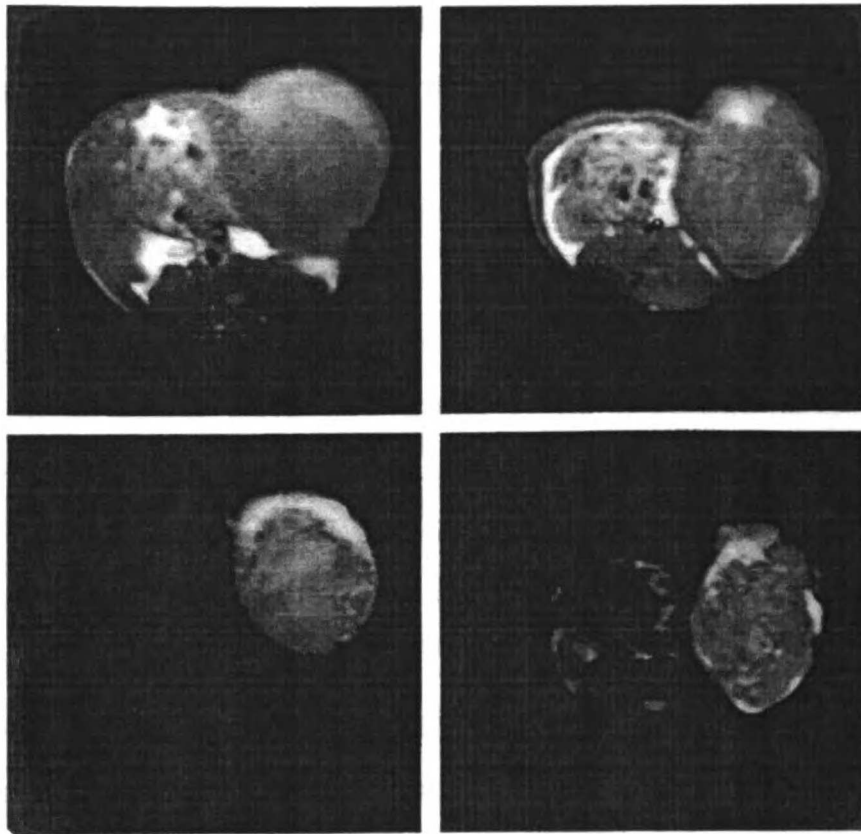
Comparison of T1-weighted (top) and T2-weighted (bottom) ^1H MR images of hormone-sensitive (left) and hormone-resistant (right) tumors. T1-weighted images were obtained with 4 acquisitions, a TR of 500 msec, a TE of 14 msec, an FOV of 8 cm x 8 cm, a slice thickness of 3 mm, and a 128 x 256 pixel matrix. T2-weighted images were obtained the same way except that 2 acquisitions were used with a TR of 2500 msec and a TE of 80 msec.
